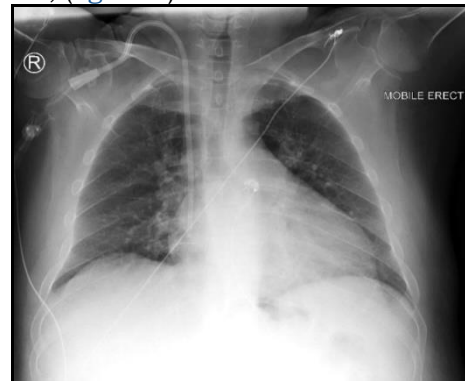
Chest x-ray post insertion of tunnelled vascath of Rt subclavian vein.
